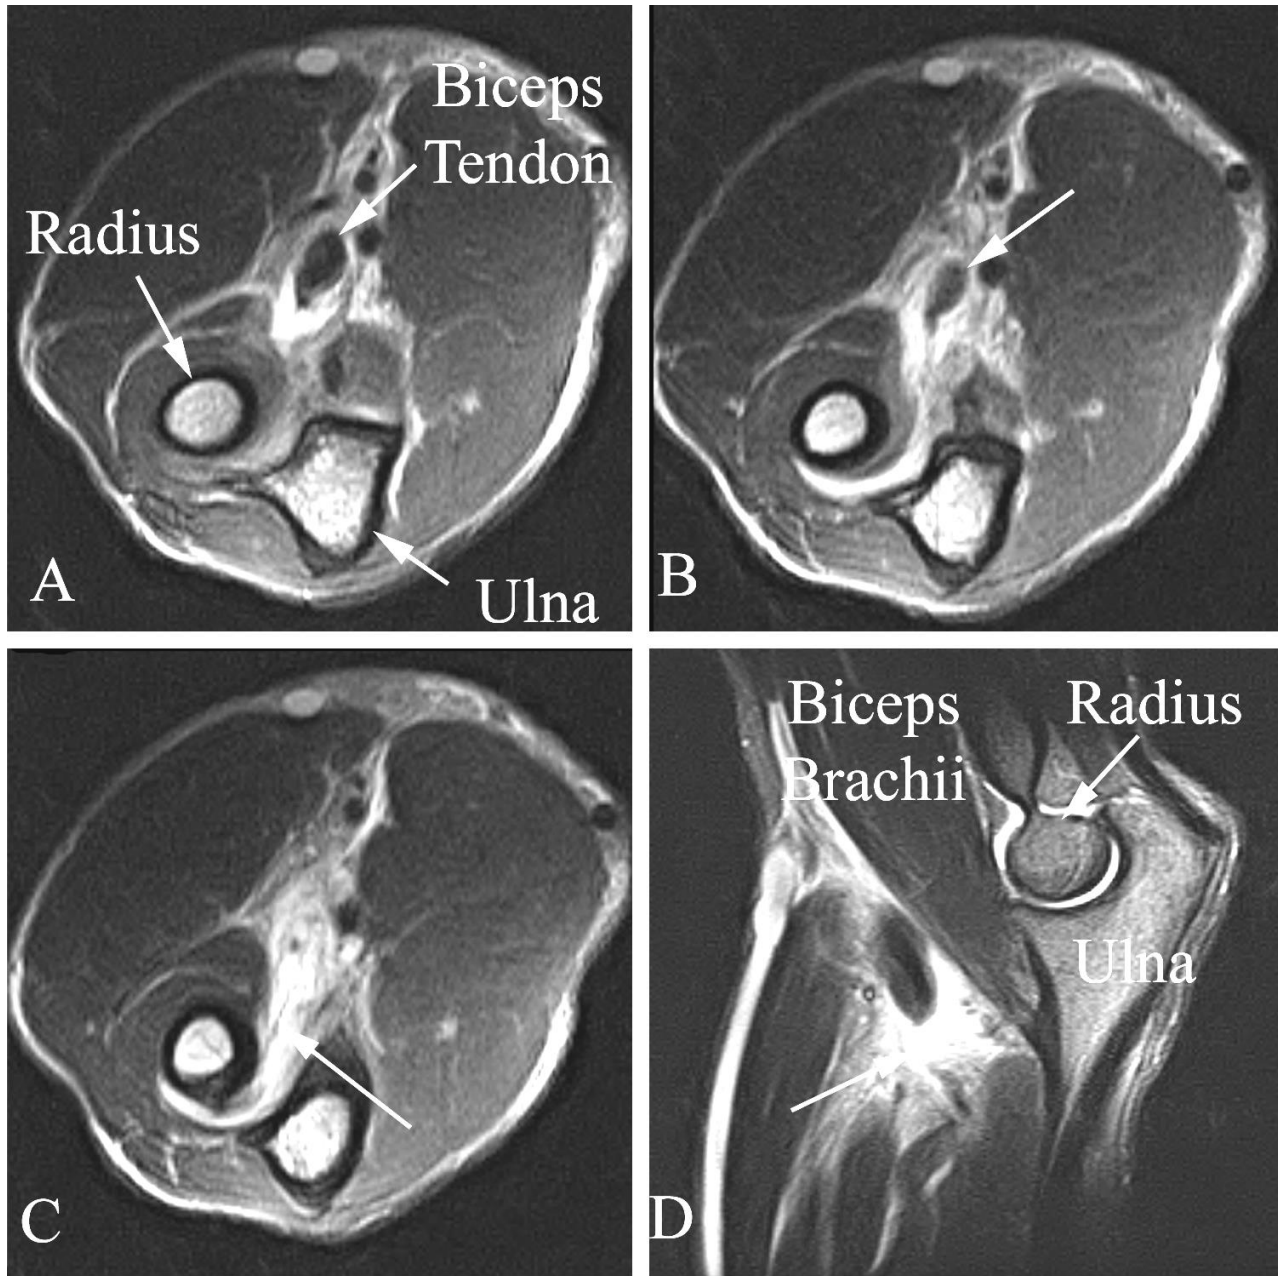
Biceps tendon rupture in a 47 year old man who had acute pain in the elbow following a lifting injury. A. Axial T1 weighted MR image demonstrates a swollen distal biceps tendon (arrow). B. Axial T1 weighted MR image slightly more distal in the arm demonstrates rapid tapering and an irregular appearance of the biceps tendon (arrow), particularly along its deep aspect. C. Axial T1 weighted MR image slightly more distally shows that the biceps tendon is absent (arrow) compatible with tearing and proximal retraction. D. Sagittal proton density MR image shows the tear through the distal biceps tendon (arrow) with retraction of the torn tendon margin.
